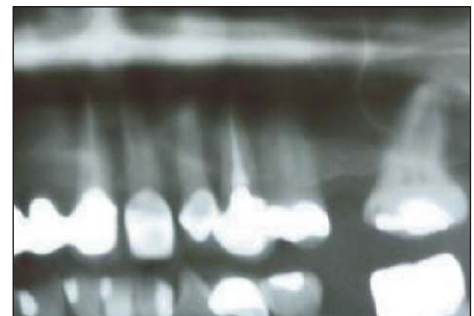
To minimise trauma and bone damage study x-rays to establish the orientation of the tooth in relation to the patients bone structure. In particular: The location of the maxillary sinus in relation to the tooth, 2nd and 3rd molar in maxilla and risk of fracture of maxillary tuberosities as well as nerves and blood vessels in the mandible.
